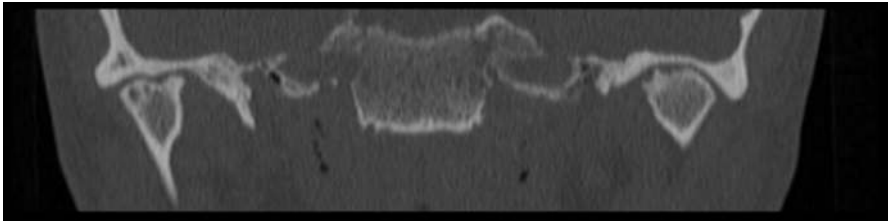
Osteoarthritis of TMJ. Bilateral signs of erosions on the surfaces of the condyles in a coronal view of the CT. Subchondral cyst in the right condyle. The joint spaces are asymmetric.
